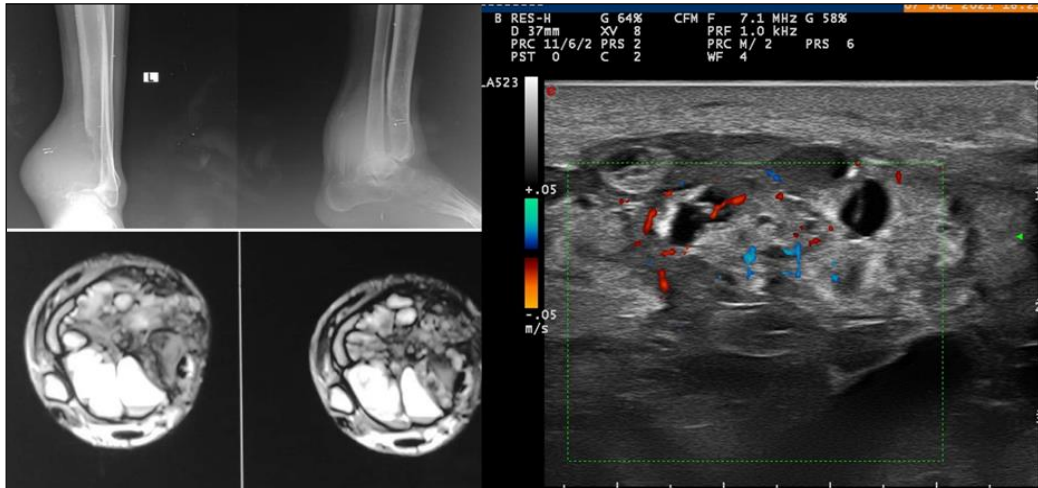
31M Grossly expansile eccentric lytic lesion on radiograph. The wall is imperceptible laterally with no internal trabeculation (Grade III). Lesion is heterochoic with increased vascularity on USG, MRI shows fluid-fluid level s/o secondary ABC
